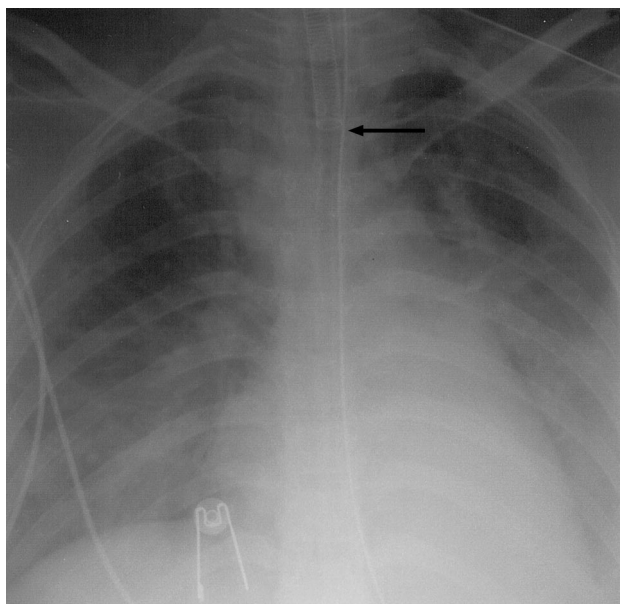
Radiograph after repositioning endotracheal tube (ETT). The wire coil in the ETT (arrow) ends at the clavicular level so that the end of the ETT is 2 cm above the main carina. Atelectasis is resolving.
